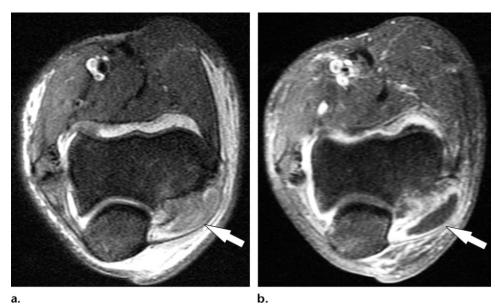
Myonecrosis in a 36-year-old woman with systemic lupus erythematosus presenting with elbow pain. (a) Axial T2-weighted fat-suppressed MR image shows edema (arrow) in the anconeus muscle with overlying subcutaneous tissue edema extending anteromedially. (b) Axial postcontrast T1-weighted fat-suppressed MR image demonstrates peripheral enhancement (arrow) of the anconeus muscle with a central area of nonenhancement, consistent with myonecrosis.
